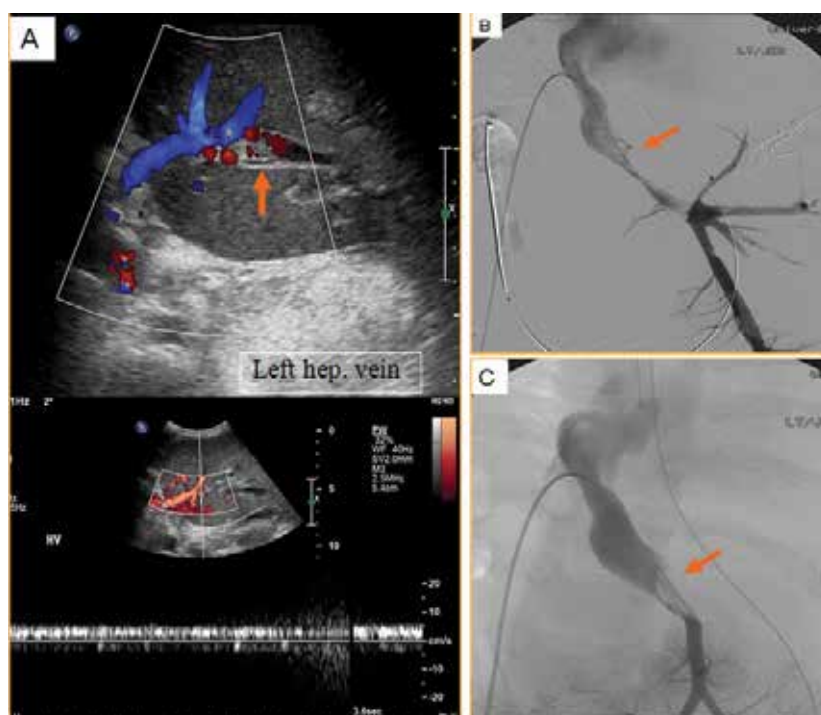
Management of hepatic vein stenosis\ thrombosis. (A) Doppler US reveals thrombus in the left hepatic vein (arrow) with abnormal monophasic flow. (B) Hepatic venogram reveals patent hepatic veins-IVC anastomosis and non-occlusive thrombus (arrow) in the hepatic vein confluent. (C) After local thrombolysis, thrombectomy and venoplasty, improved flow with residual thrombus (arrow)
